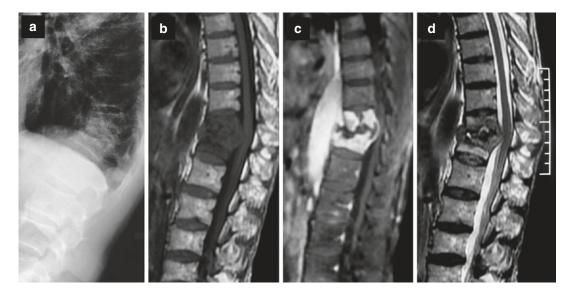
Thoracolumbar Pott's disease. Plain radiography (a), sagittal MRI on T1-weighted image before (b) and after gadolinium injection (c) and on T2-weighted image (d) (Note the conus medullaris compression)
